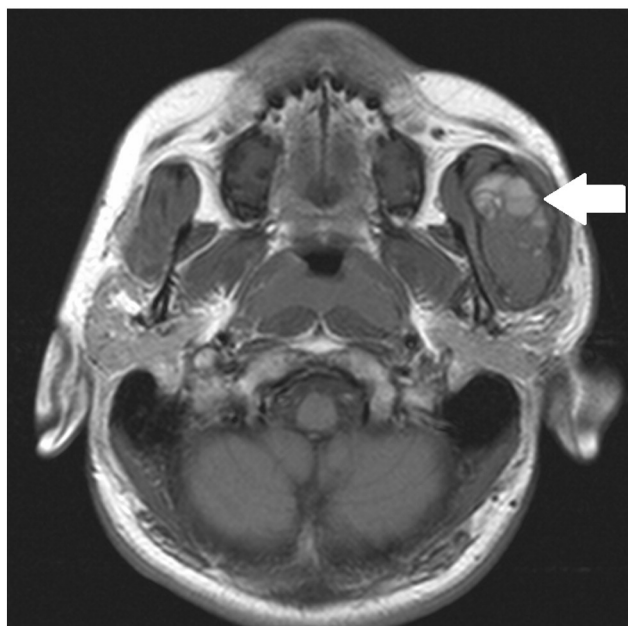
Axial T1 weighted (T1W) MR scan image. The high signal in the upper parts of the lesion is suggestive of blood products. Around the lesion, there is no signal, according to the thin bone border on the CT (arrow).
